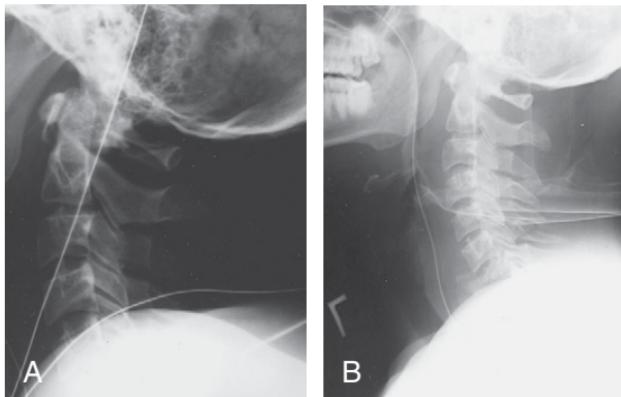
This pair of pictures demonstrates the inadequacy of a C-spine film when the C7 vertebra is not visualized (A). A repeat lateral x-ray shows a burst fracture of C7 (B).
